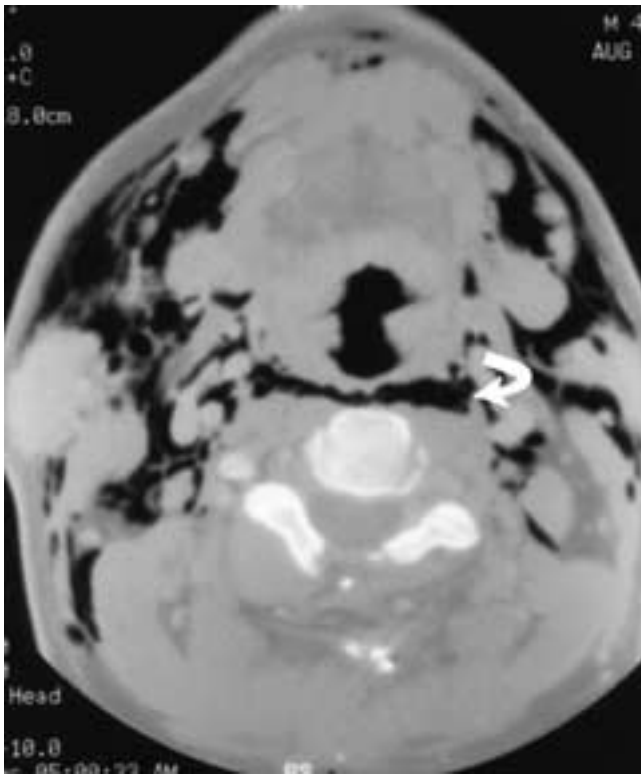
Axial CT scan obtained following penetrating trauma shows air dissecting along the fascial planes. Note the air extending along the retropharyngeal space (arrow).
